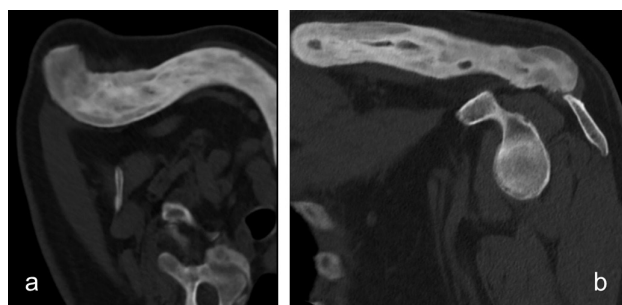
On computed tomography, a diffuse enlarged clavicle, with cortical thickening and coarse bone trabeculae is seen in axial view (a) and in coronal view (b).
